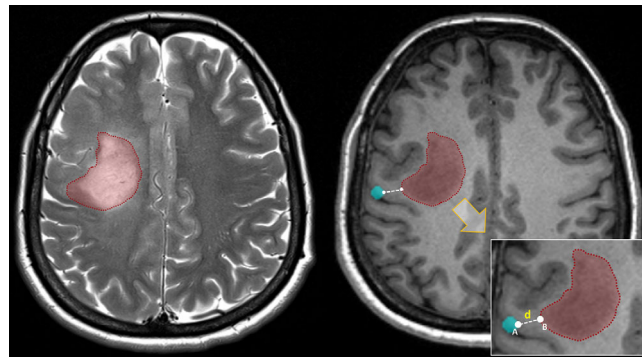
The shortest distance from the tumor to the language network (SDTN). The left panel was T2-weighted image and the region of high signal represents the glioma (red region). The right panel was T1-3D image and the red region was the same as in the left panel and represented the glioma. The blue region represented a node of the language network that was left hemispheric Brodmann area 4 (A4hf, head and face region). This node was nearest to the glioma for this patient. The point A and point B were the points that respectively located on the node A4hf and the glioma. The dotted white line (d) represented the shortest distance that was calculated based on the coordinates of the point A and point B
